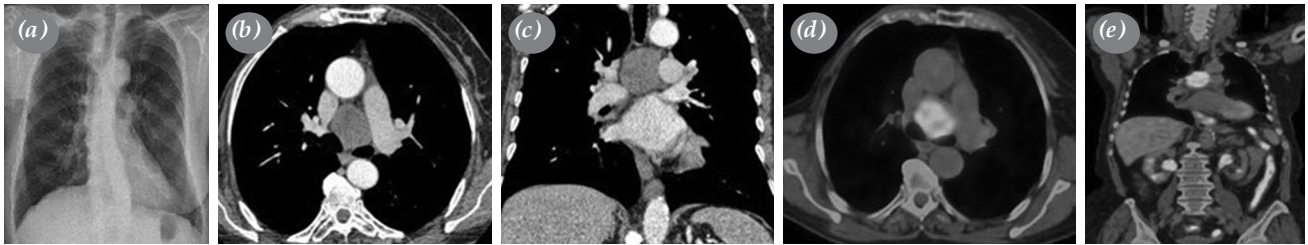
(a) Preoperative PA lung X-ray. (b) Preoperative axial thorax CT image. (c) Preoperative coronal thorax CT image. (d) Preoperative axial PET-CT image. (e) Preoperative coronal PET-CT image.
